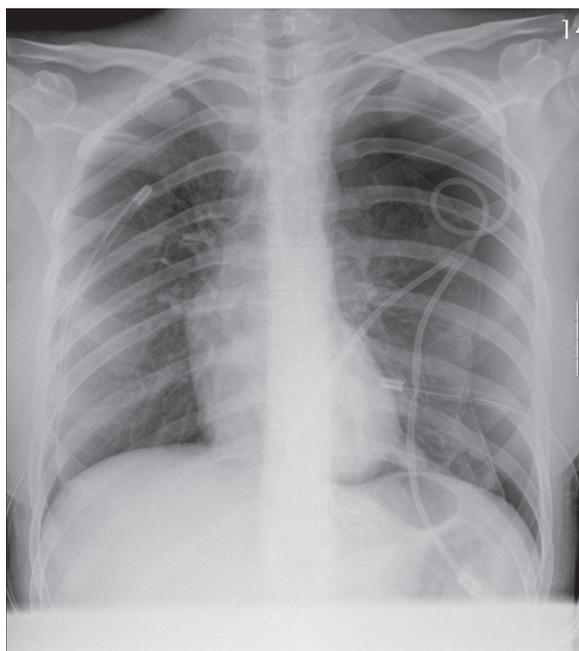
Plain film, bilateral pneumothorax with drainage, discrete metastatic nodules.
